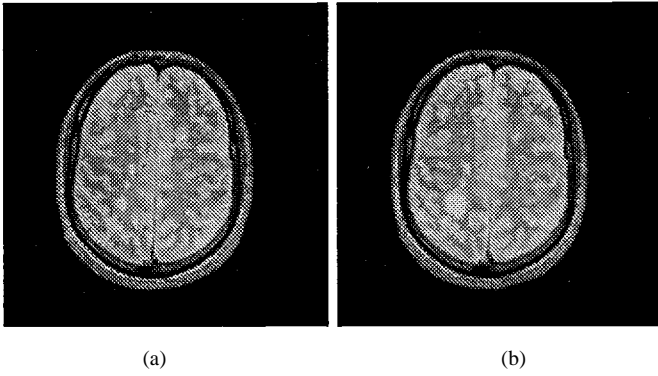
Two registered slices of a patient with MS, with a two-months interval (T_2 -weighted first echo MRI).
